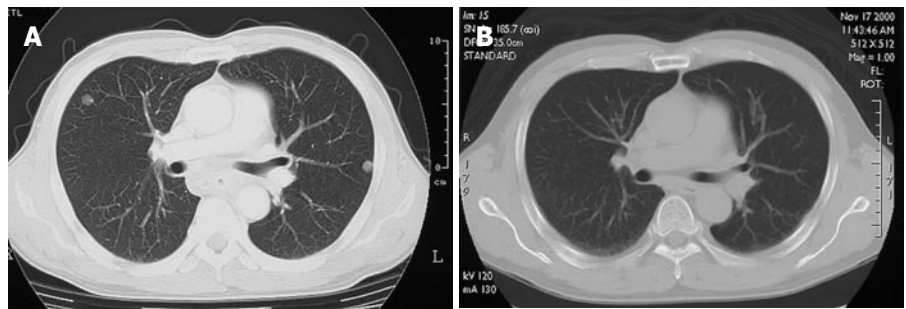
A chest computed tomography scan before (A) and after (B) chemotherapy. Complete disappearance of the multiple nodules in the bilateral lung was revealed during chemotherapy, defined as complete response^[3].
